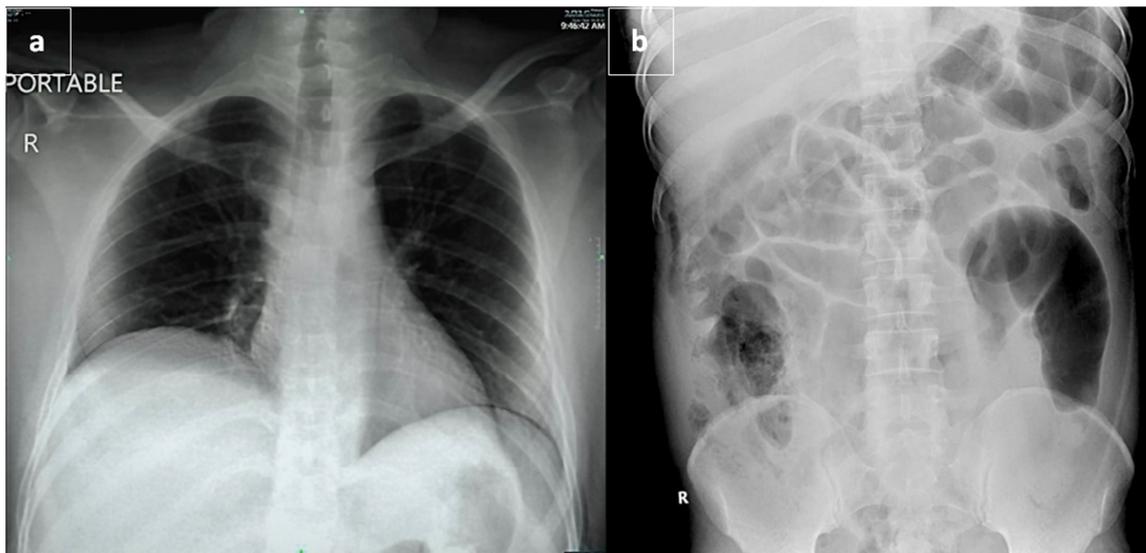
Portable x-rays on day of admission: (a) Chest x-ray (CXR) with unremarkable findings. (b) Abdominal X-ray (AXR) showing distended bowel full of gases.
